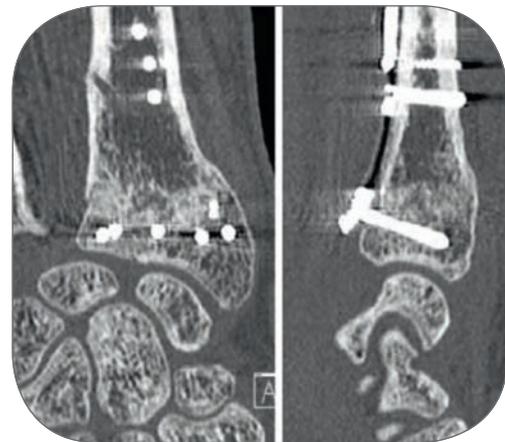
CT scan: 16 weeks post-op, second operation
